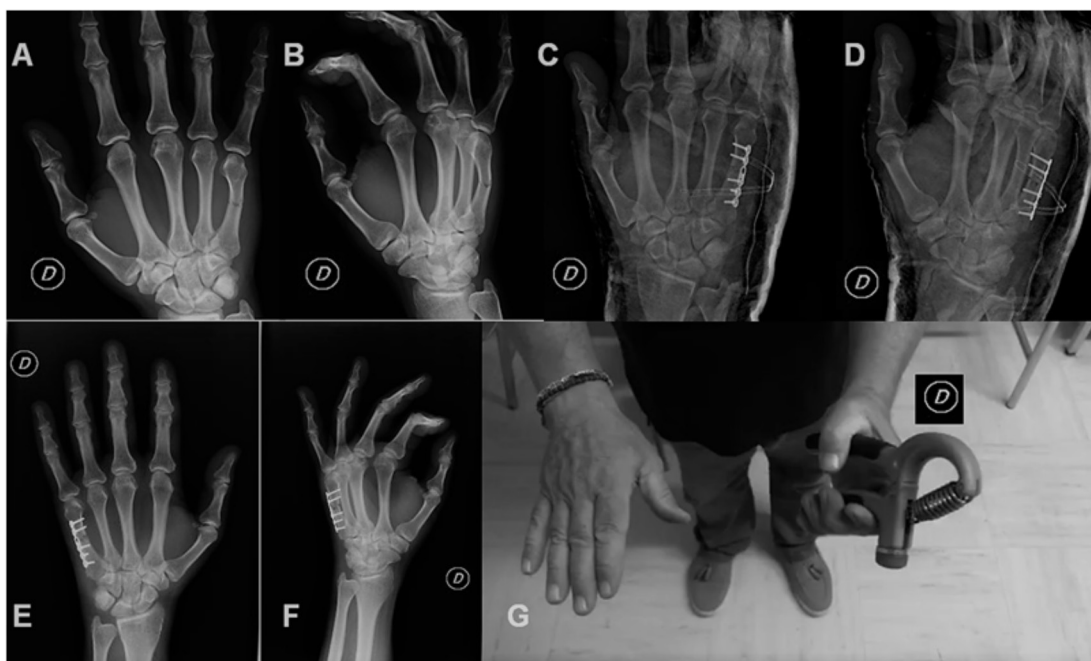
A 42-year-old male with transverse fracture of the right V metacarpus from fist. A, B) Pre-operative X-rays show the above fracture in detail; C-D) postoperative X-rays show the surgical treatment with plate and screws; E-F) control X-rays at 6 months; G) result in the grip test at 6 months (Pasquino A, 2018)
